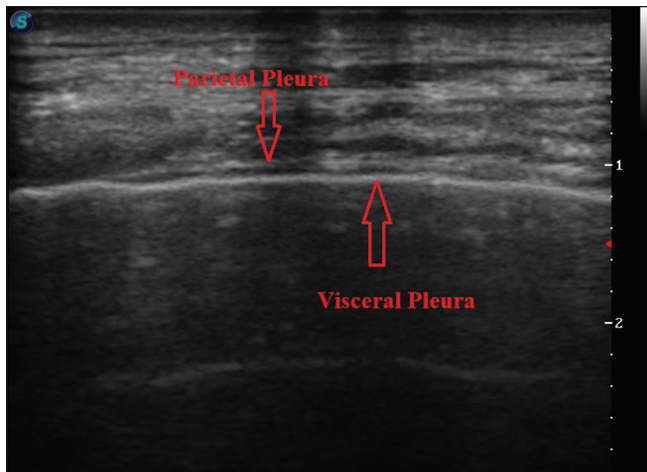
Thoracic ultrasonographic imaging with a 10 MHz linear probe view of the pleura in the superficial mode.
